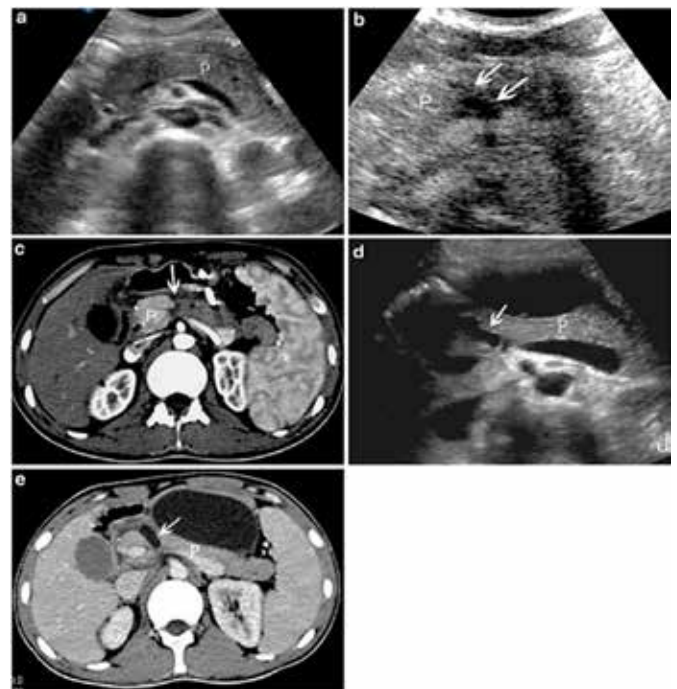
Pancreatic trauma in adults. Images "a" and "d" are from ultrasound, "b" is from ultrasound with contrast, "c" and "e" are from computed tomography<sup>4</sup>.
